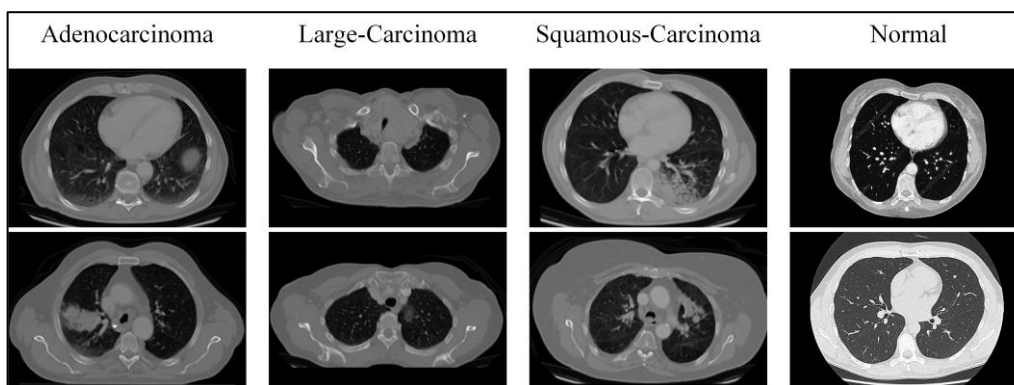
Four categories of lung CT image classes
